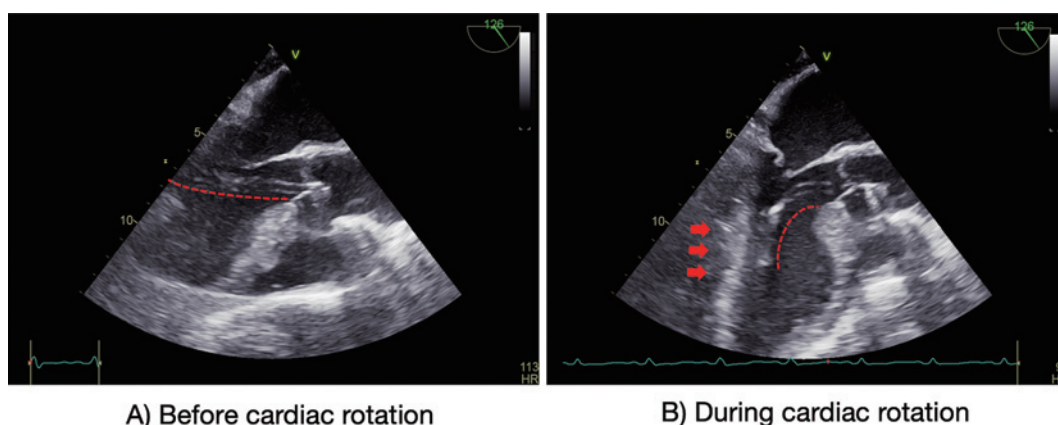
Transthoracic echocardiography of Impella positioning in Case 1
